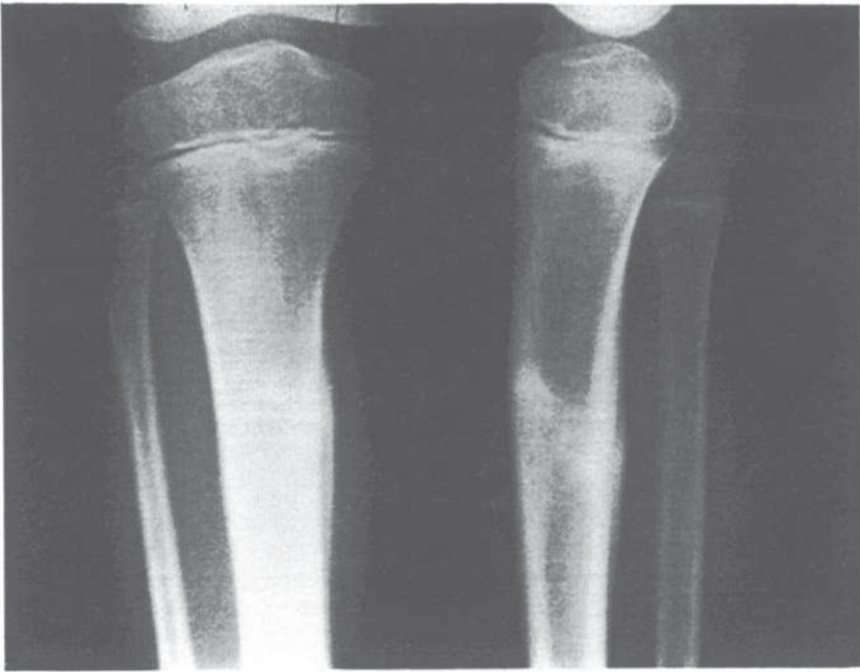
X-ray photographs of stress fractures in the tibia
